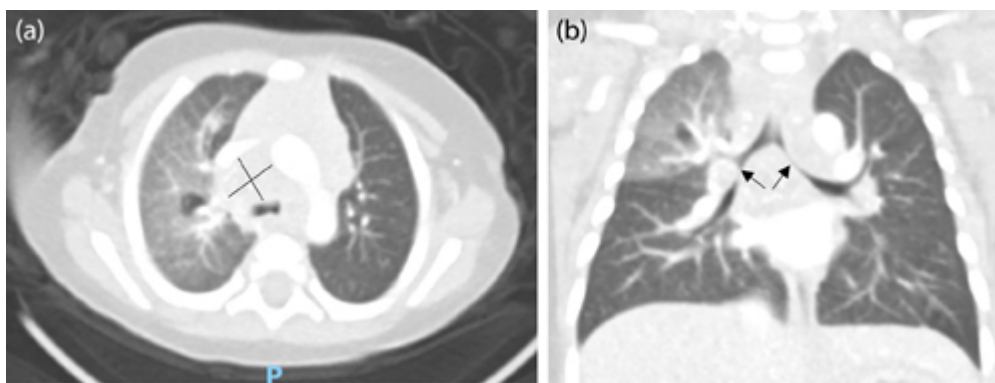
(a) CT thorax showing enlarged lymph nodes, especially at the right paratracheal region, measuring approximately 2.1×1.6 cm. (b) CT thorax showing narrowing of the bilateral main bronchi secondary to compression from enlarged lymph nodes, more on the left. ↩
